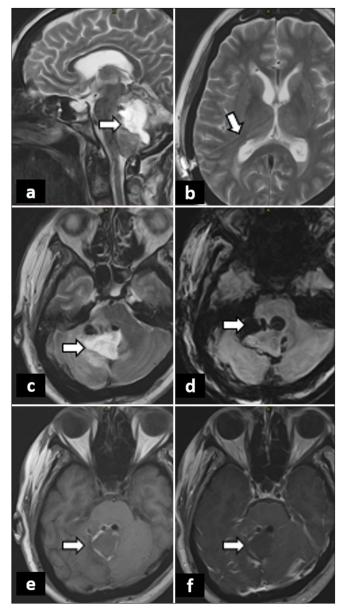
Postoperative magnetic resonance imaging findings after the second surgery. (a). Sagittal T2-weighted image reveals a resection cavity (arrow). (b). Axial T2-weighted image shows a ventricular drain in place (arrow). (c). Axial T2-weighted image also reveals a resection cavity (arrow). (d). Susceptibility-weighted image (SWI) shows marginal susceptibility and pneumocephalus (arrow). (e). Axial T1-weighted image shows marginal hyperintensity, indicating hemorrhage (arrow). (f). Axial T1 postcontrast image shows subtle reactive enhancement along the resection cavity (arrow), representing postsurgical changes. No discrete residual disease was appreciated on imaging.
